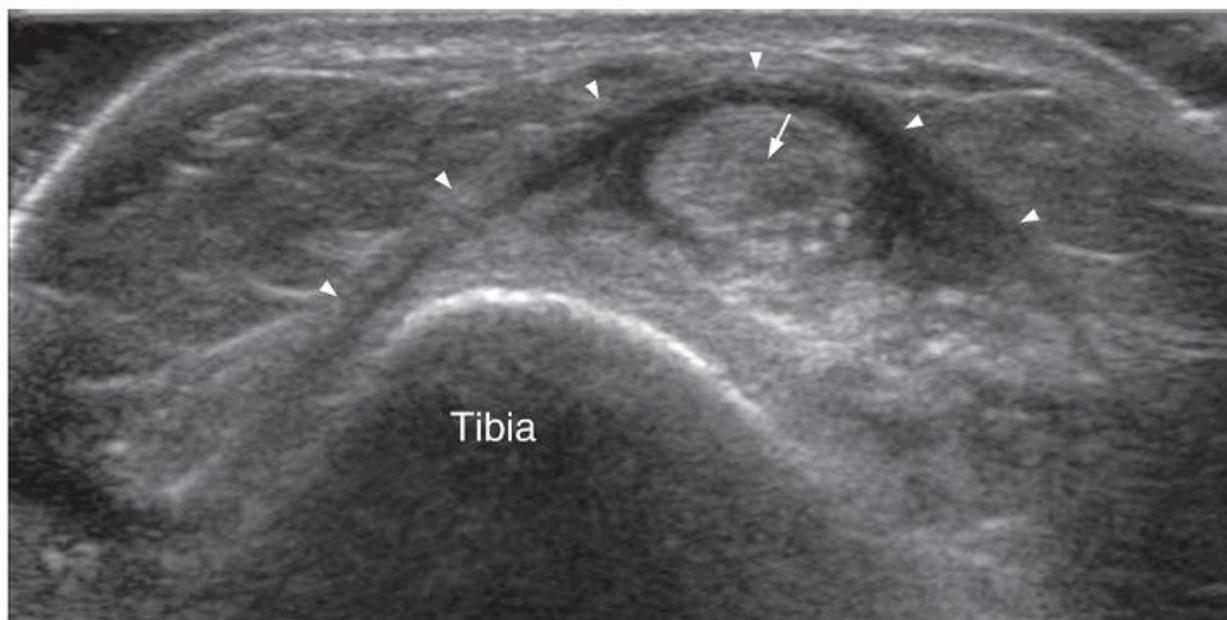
Transverse ultrasound of the ankle joint showing a severe tendinosis of the tibialis anterior tendon (arrow) with diffuse tendon thickening and a surrounding tendon sheath effusion and peritendinitis. Note the overlying thickened superior retinaculum (arrowheads).
